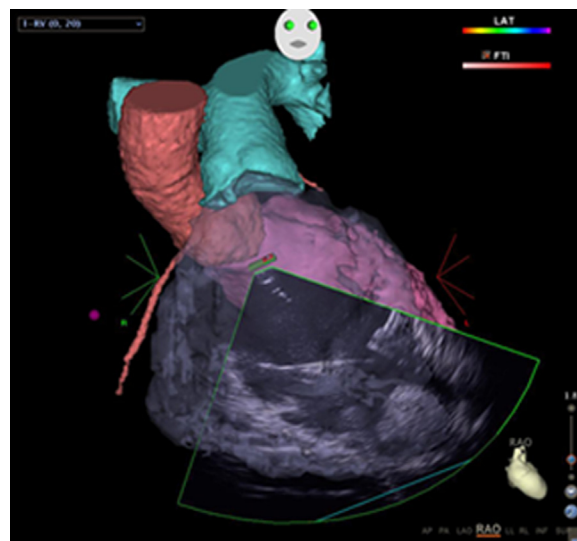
An image of the right ventricle created using intracardiac echocardiography merged with computed tomography. The fusion image reveals a large thrombus in the right ventricular apex.
